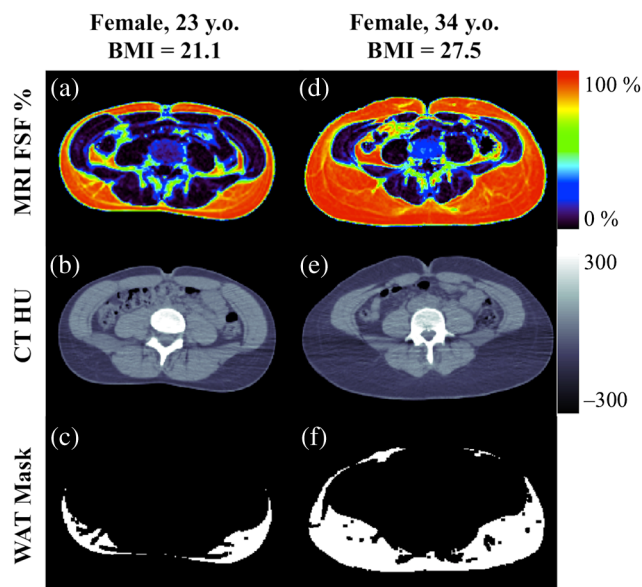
Axial slices at the umbilicus level of two female subjects: (a)–(c) with a low BMI and (d)–(f) with a high BMI. (a) and (d) The fat–water MRI-derived fat signal fraction (FSF) in percent. The coregistered CT Hounsfield unit (HU) images for each subject are shown in (b) and (e). The corresponding subcutaneous white adipose tissue (WAT) masks are shown in (c) and (f). The rules used to generate the WAT masks are based on FSF and HU values, may exclude fascia, and use boundary erosion to reduce partial volume effects, thereby resulting in a conservative estimate of WAT.
